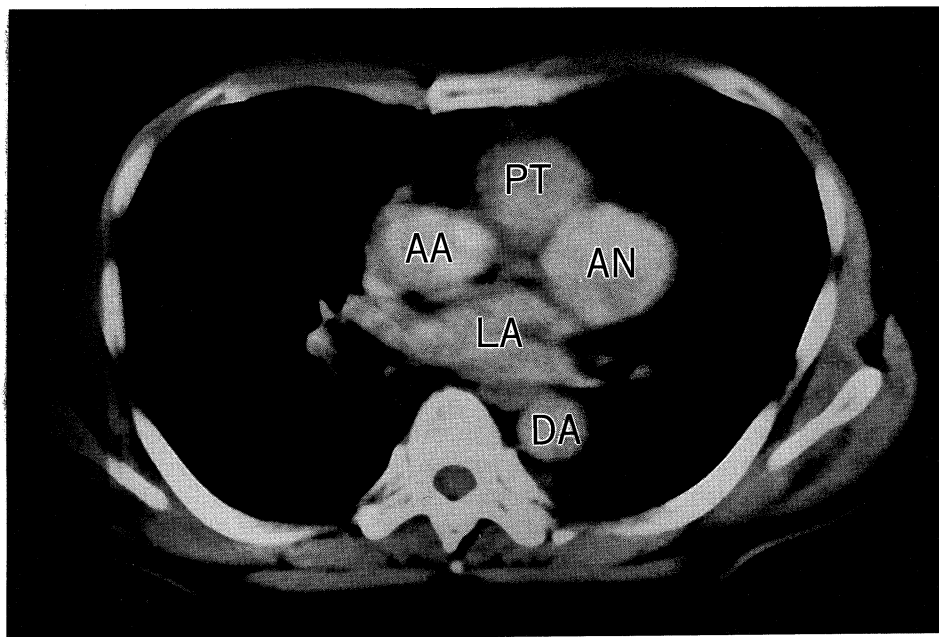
Contrast-enhanced CT scanning, demonstrating a 4×5 cm aneurysm (arrow) on the left posterior aspect of the pulmonary trunk.
